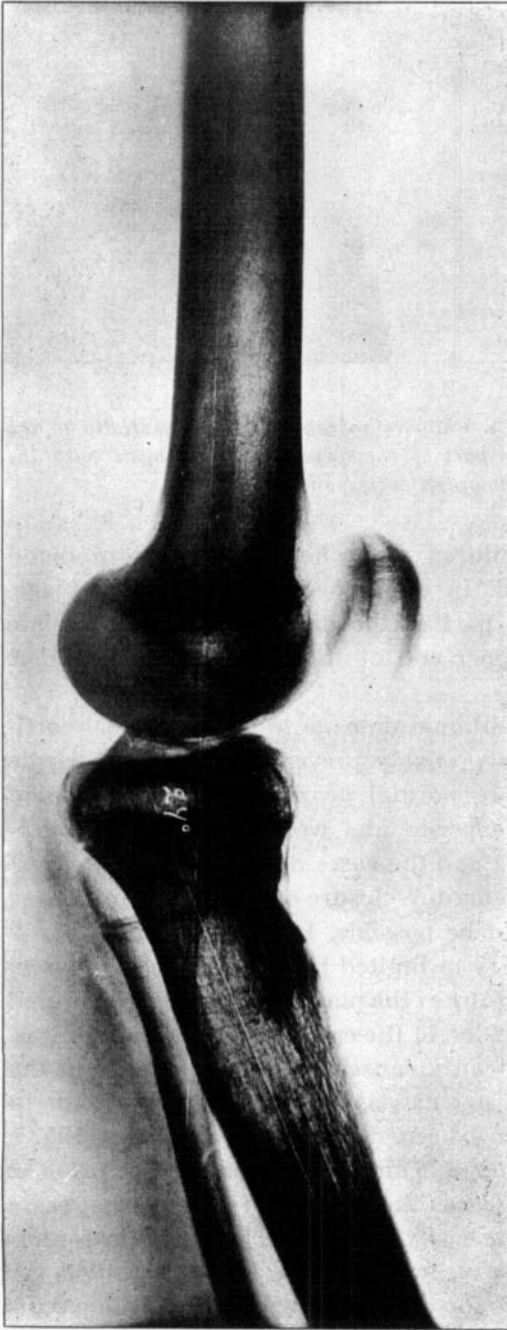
Case 2. Age fifteen years. A. Plain radiograph taken tangentially to the bony bridge connecting the anterior part of the upper tibial epiphysis with the metaphysis, B. Tomograph corresponding to A.
